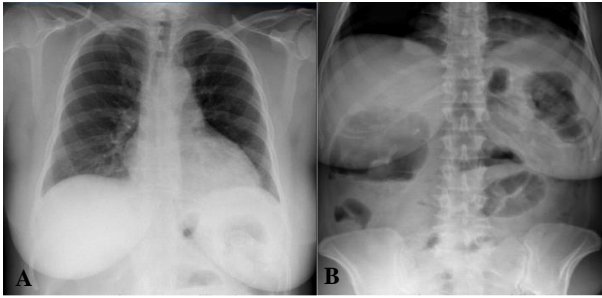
(A) Chest and (B) abdominal radiographs.
